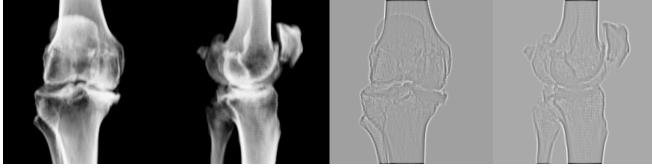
Original x-ray images and their Laplacian of Gaussian images.
